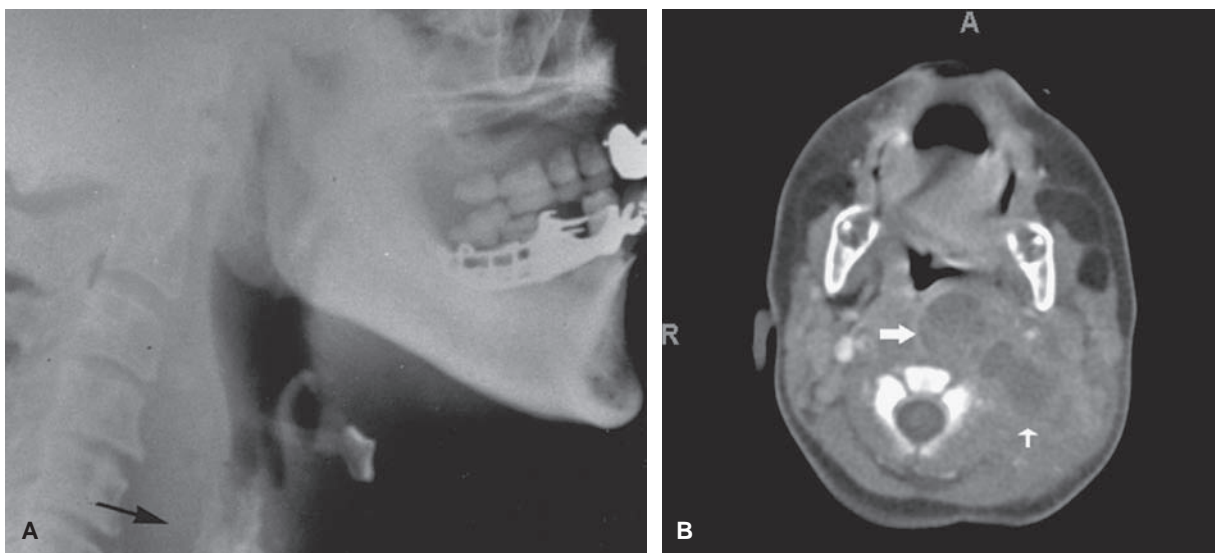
A: A lateral neck radiograph demonstrating retropharyngeal abscess (*arrow*). B: A computed tomographic scan of neck with contrast demonstrating a retropharyngeal abscess (*large arrow*) and smaller, contiguous parapharyngeal abscess (*small arrow*).
